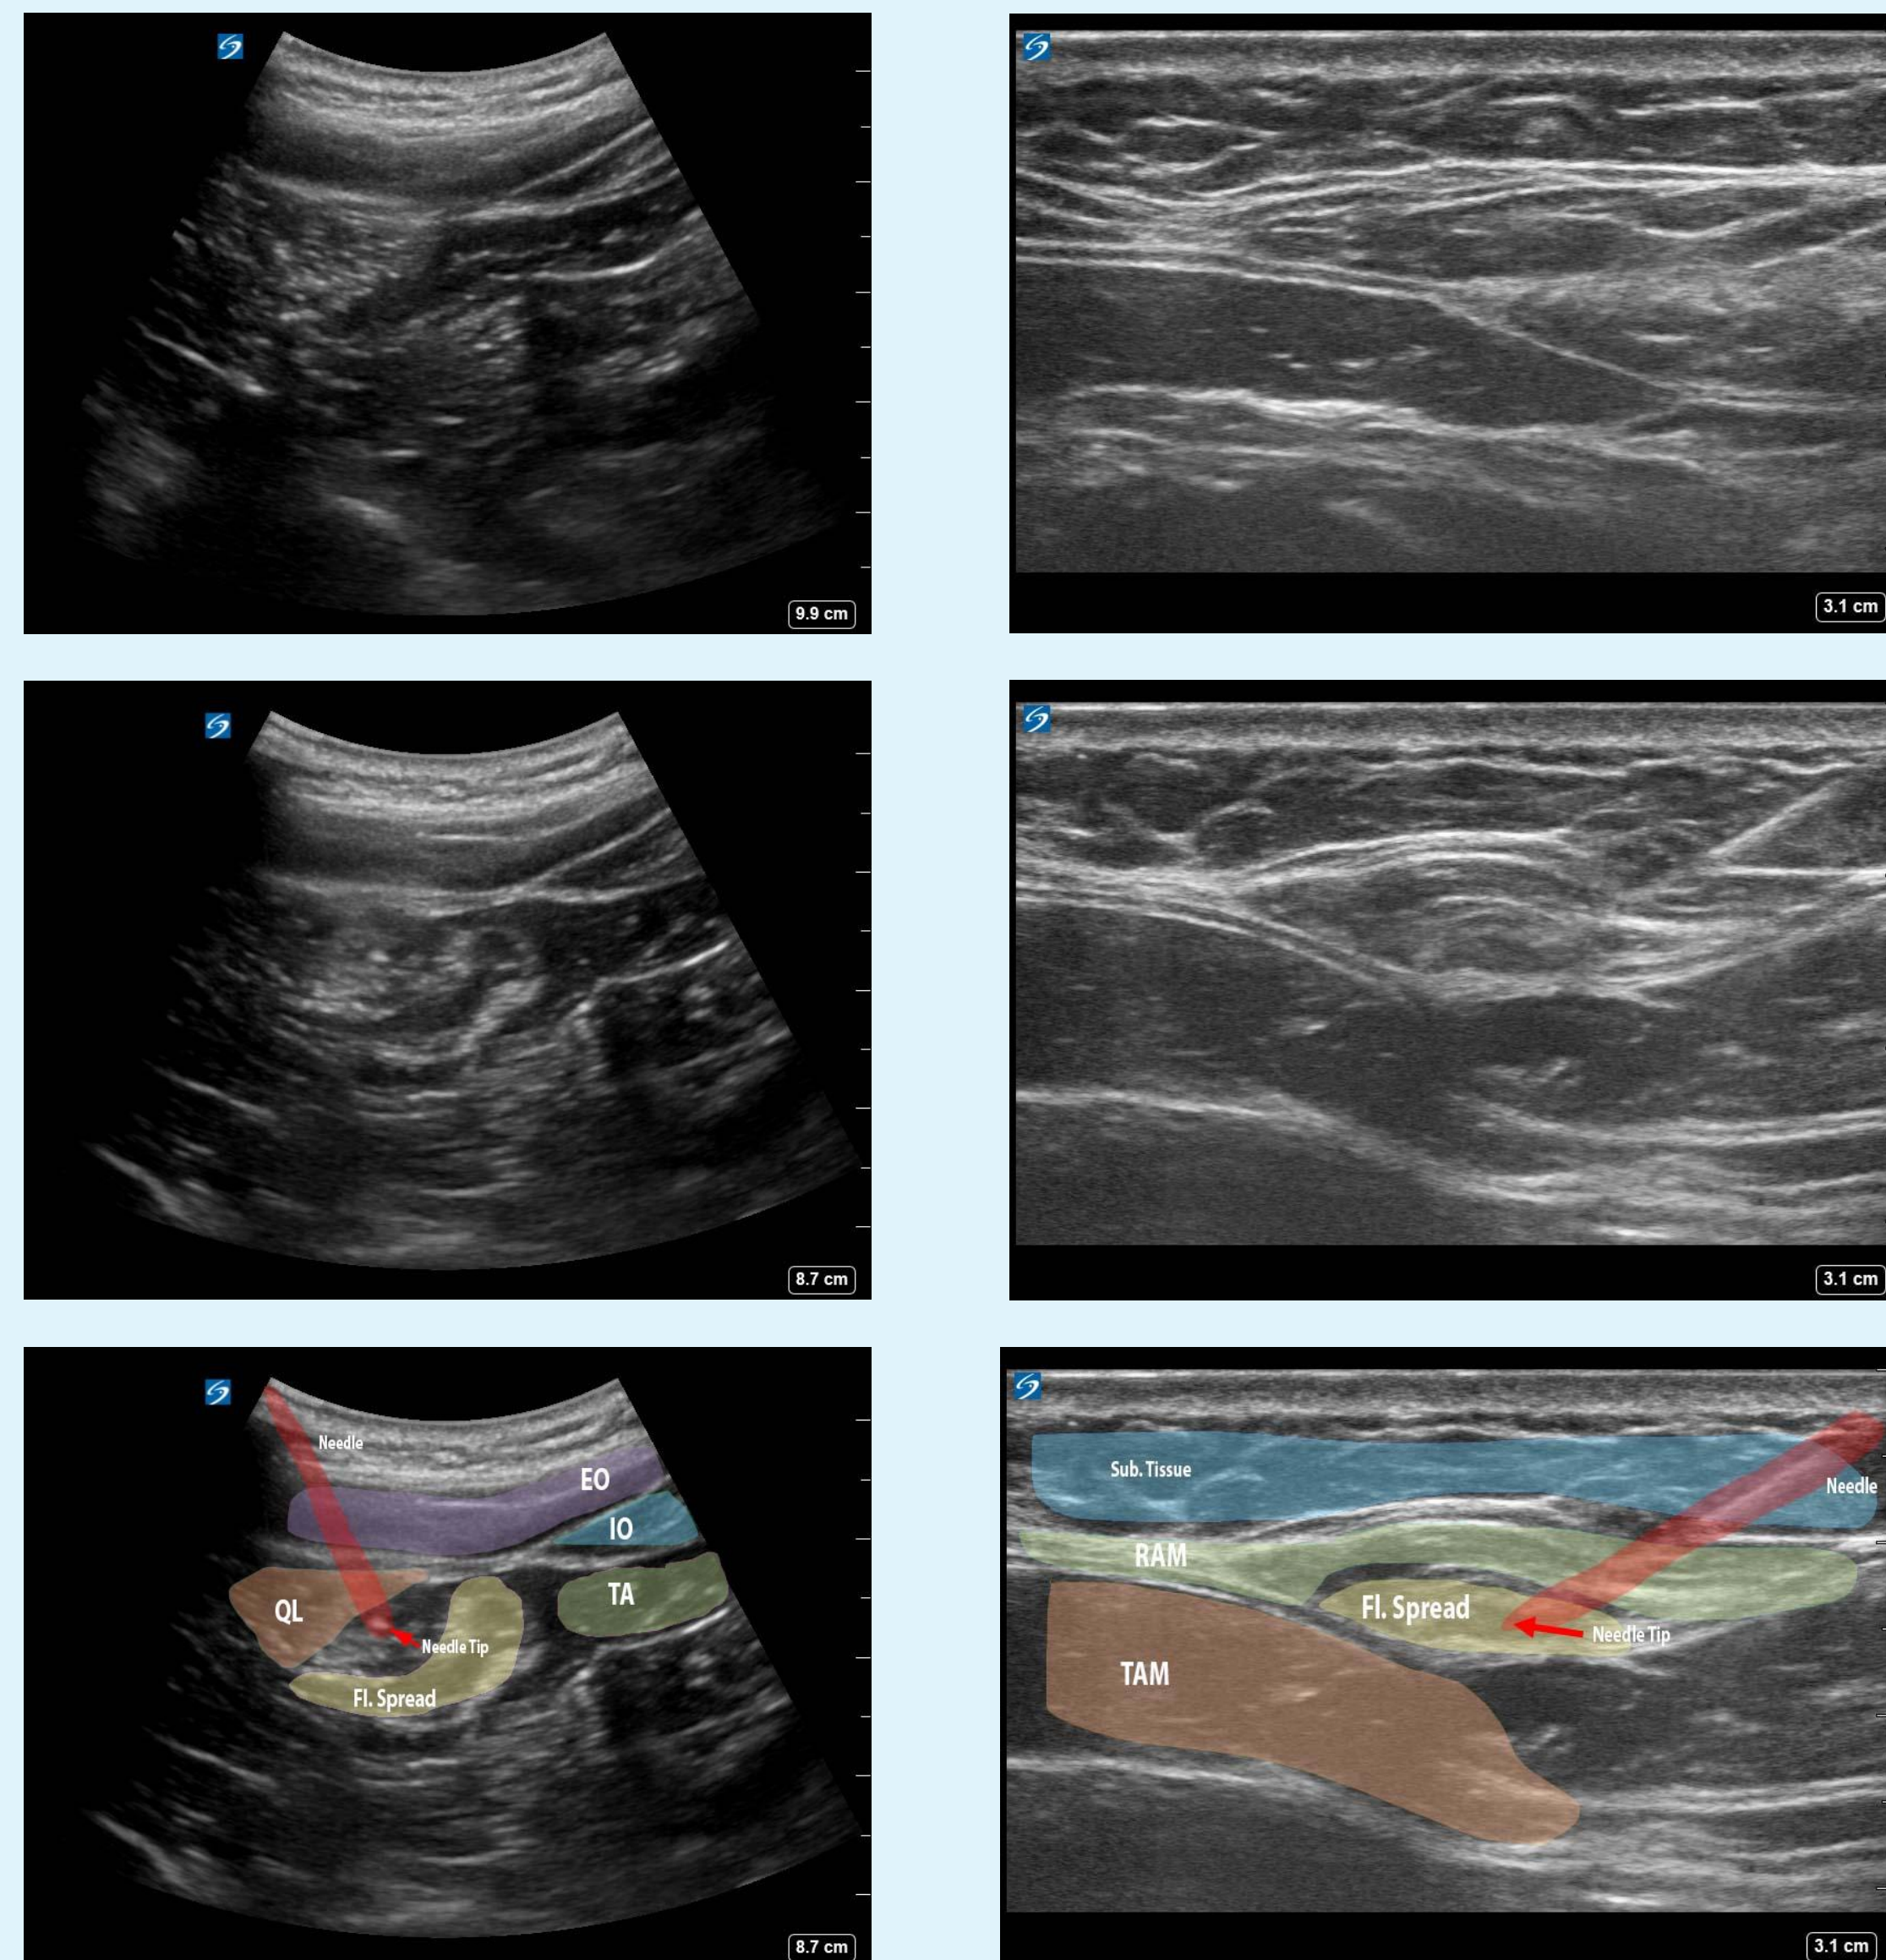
/b/c: Ultrasound imaging before and during rectus sheath block. Figure 5c shows anatomy and fluid spread with false color overlay. (Abbreviations: EO - External Oblique, IO - Internal Oblique, TA - Transverse Abdominus, QL - Quadratus Lumborum)
